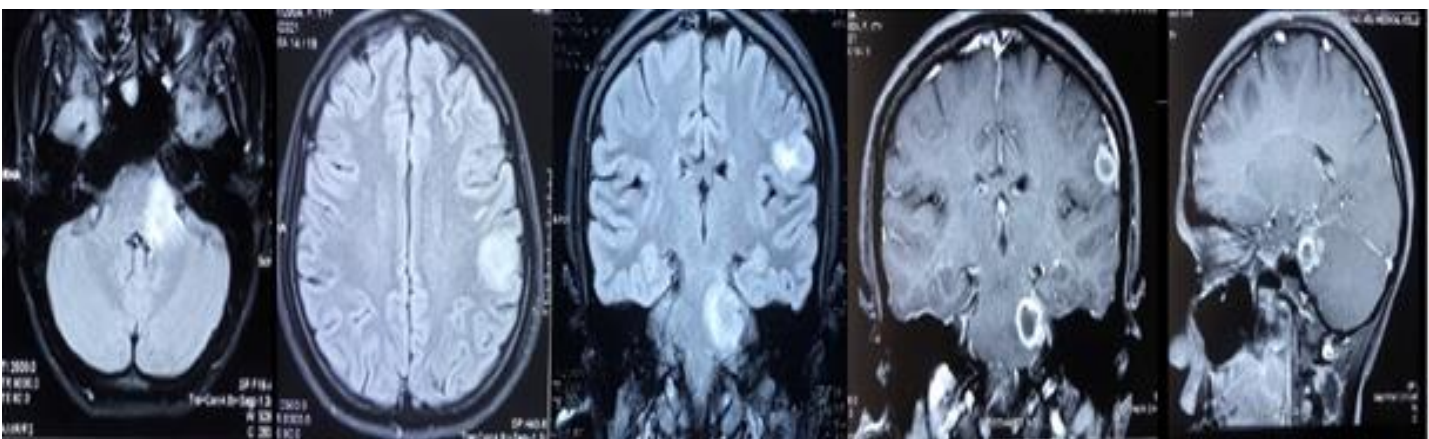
MRI showing multiple ring enhancing lesions in Left Hemi pons, Middle cerebellar peduncle, Rt Temporal, Rt Insula and Lt precentral gyrus with the largest in Lt Hemi pons with significant edema.
